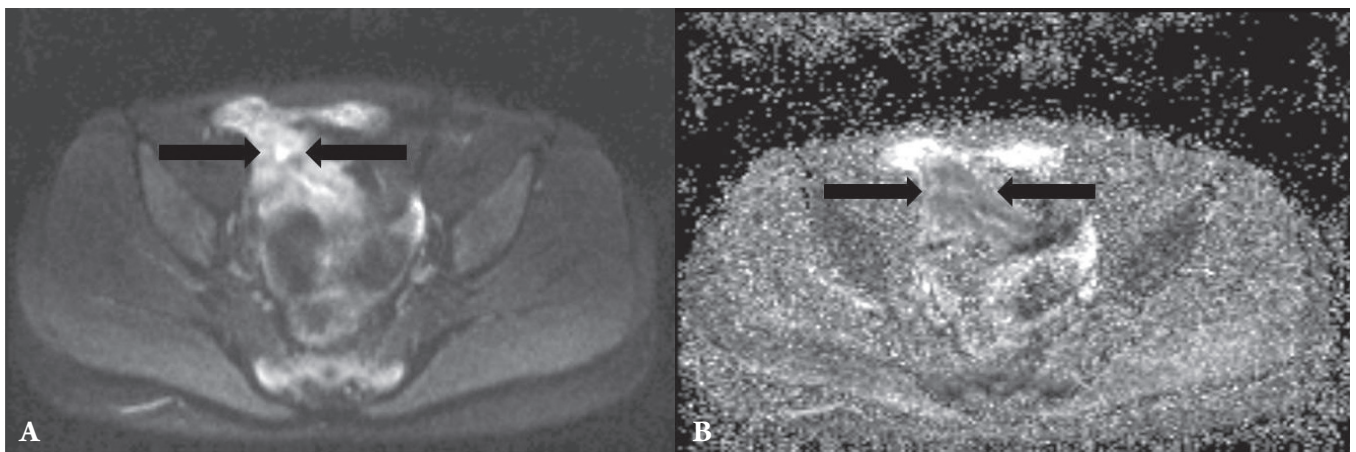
(A) Portrays hyperintensity (black arrows) on DW-MRI diffusion imaging, (B) Portrays decreased signal intensity (black arrows) on apparent diffusion coefficient (ADC) imaging corresponding to reduced calculated b values. Increased signal intensity on diffusion-weighted magnetic resonance imaging and corresponding decreased signal intensity on ADC imaging may be seen when potential fibrostenosing disease is present.
